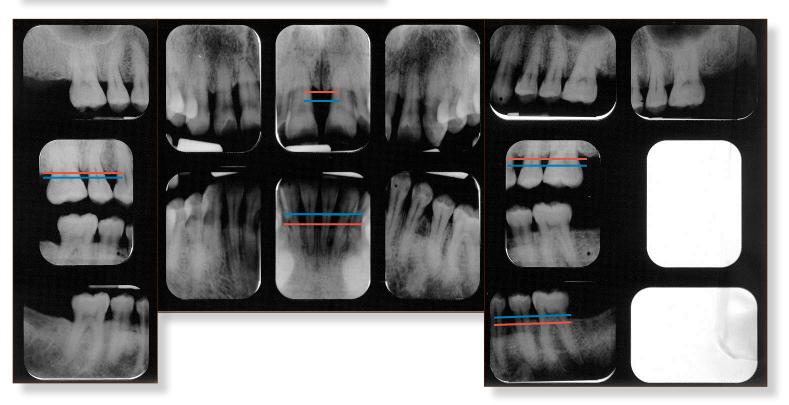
Chronic periodontitis. Full mouth radiographic survey of the patient above, showing evidence of bone loss. The space between the blue and red lines demonstrates the amount of alveolar bone loss that has occurred. Photo source: Casey Hein. Used with permission.
